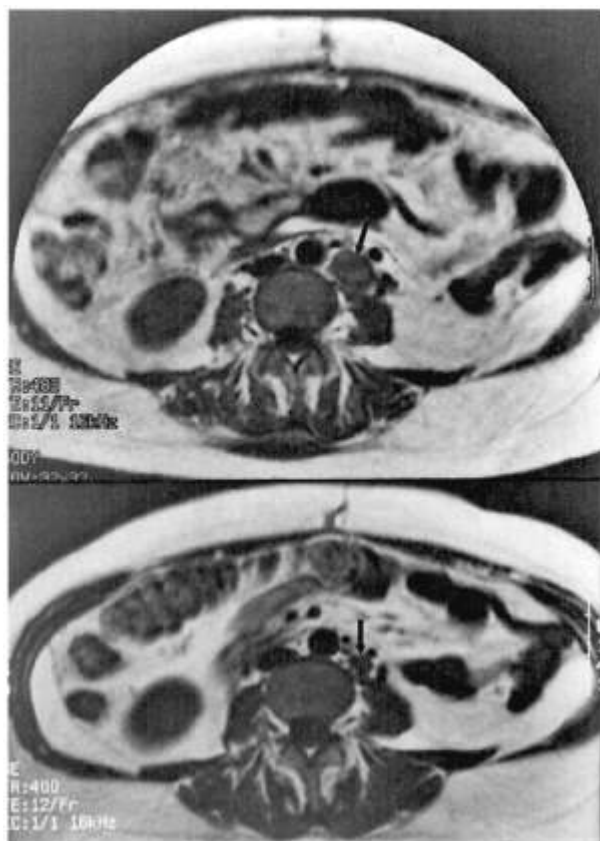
(Top) T1-weighted spin-echo abdominal MR scan on 14 July 1994 reveals enlarged metastatic para-aortic lymph node (arrow). (Bottom) Follow-up MR scan on 15 December 1994 reveals significant reduction in size of the node (arrow).
